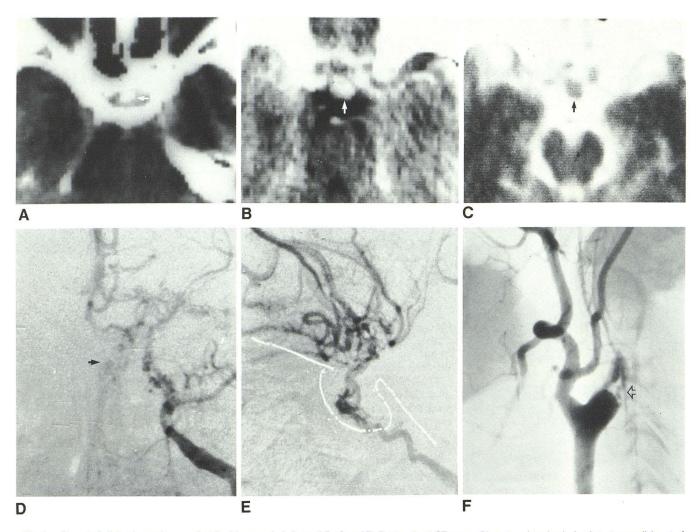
Case 1. Collateral vessels around optic chiasm and pituitary stalk. A and B, Postcontrast CT scans. Discrete enhancing lesion in anteromedial part of pituitary fossa and suprasellar cisterns (arrows). C, Metrizamide cisternogram shows corresponding filling defect in suprasellar cisterns. Bilateral carotid occlusion in left frontal (D) and lateral (E) carotid arteriograms. Stenosis of juxtasellar and occlusion of supraclinoid parts of internal carotid, proximal anterior, and middle cerebral arteries. Branches of anterior and middle cerebral arteries are filled via collateral circulation. Some collateral vascular channels are in sellar and suprasellar regions (arrow). External carotid branches are superimposed on internal carotid artery. F, Right internal carotid artery is completely occluded and thrombosed down to near its origin (arrow).
